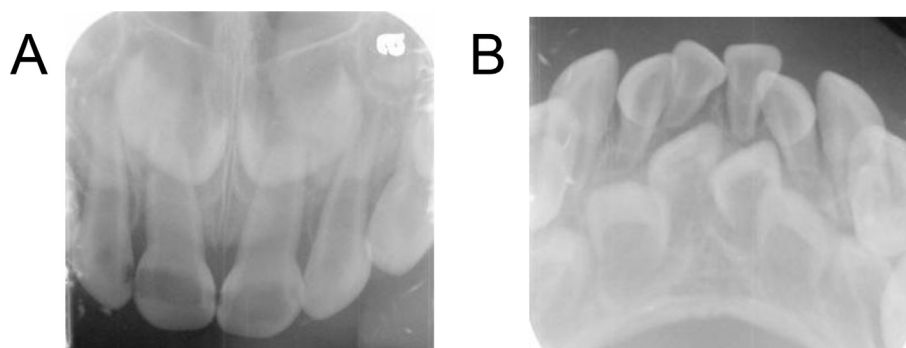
Periapical radiographs obtained at 2 years and 1 month. (A) Maxillary anterior region. (B) Mandibular anterior region.
